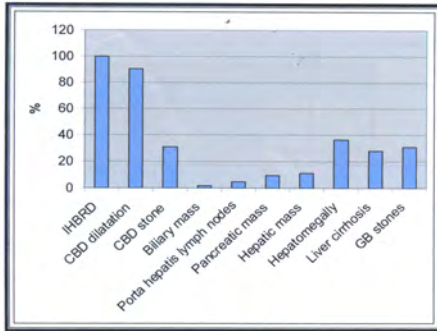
Frequency of ultrasonographic features of extrahepatic cholestasis.
